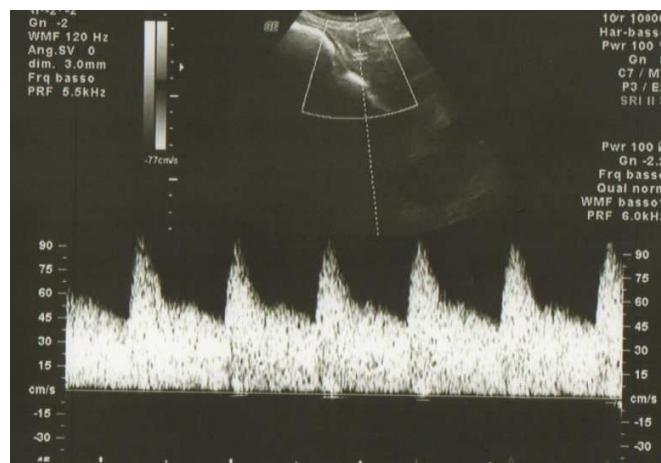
Normal uterine artery Doppler flowmetry
